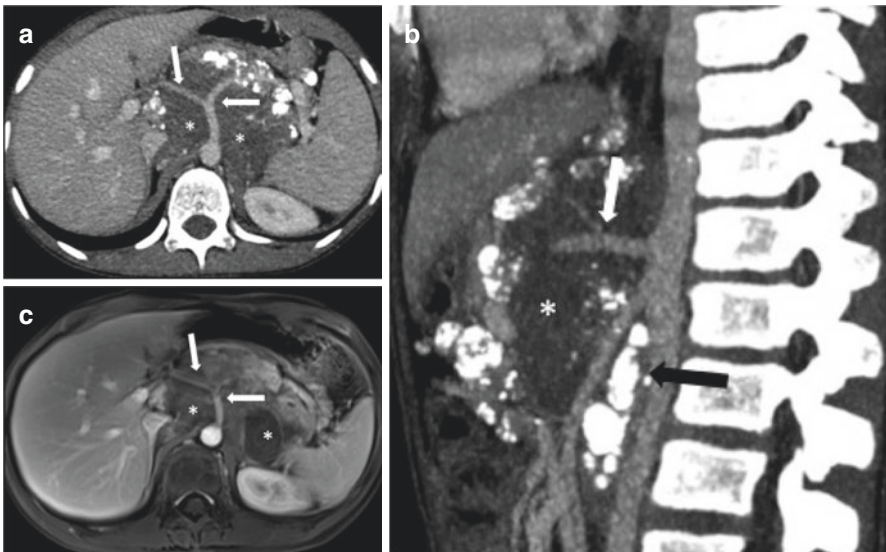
Neuroblastoma. Large retroperitoneal mass with calcifications, centered in the epigastric/mesogastric region (*), involving the celiac trunk and its branches (white arrows) on CT (a, b) and MRI (c) and widening the space between the aorta and the superior mesenteric artery (black arrow in b)
